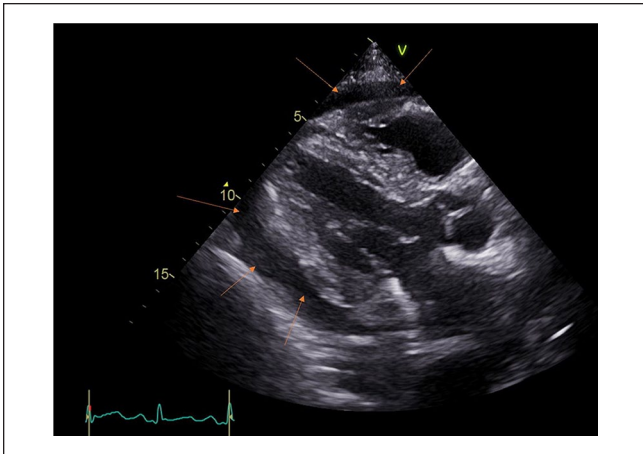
Transthoracic echocardiogram parasternal long-axis view showing moderate to large circumferential effusion (orange arrows). The patient subsequently underwent drainage of pus.
